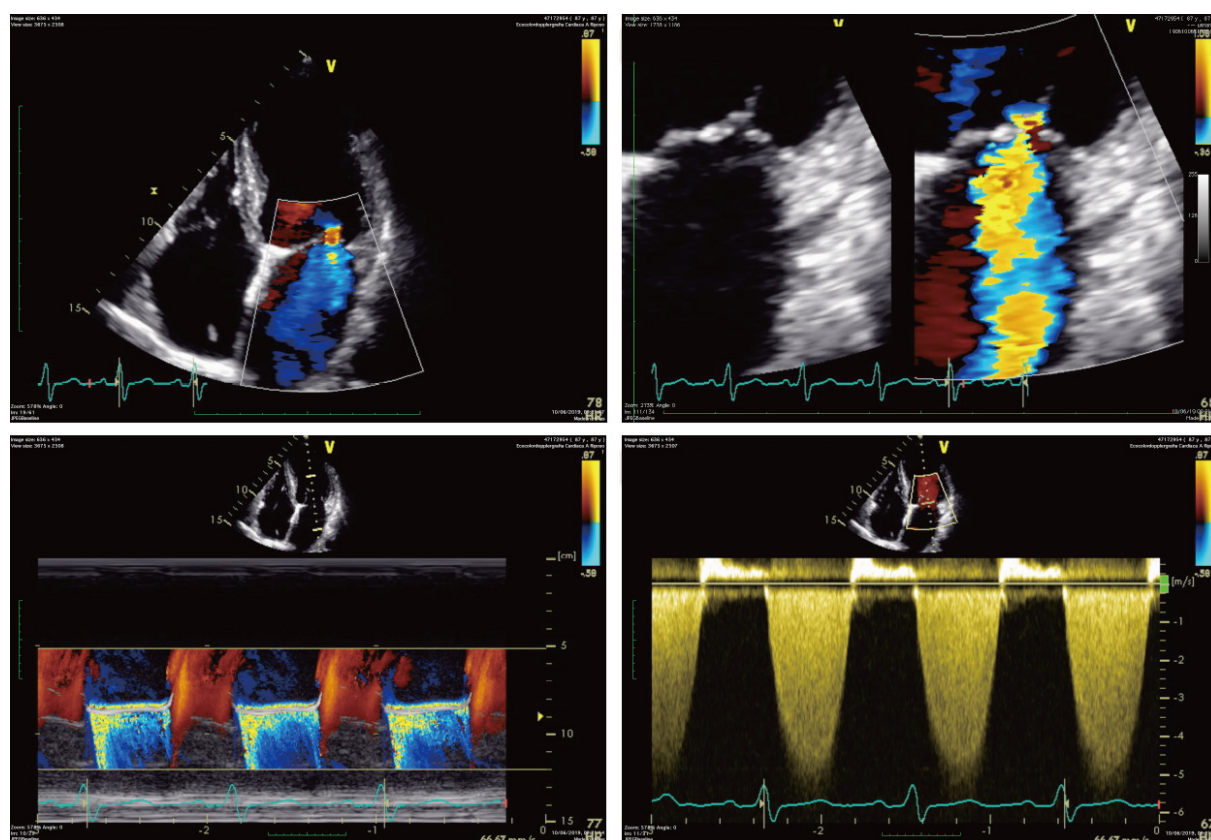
Pre-procedural transthoracic Doppler echocardiography evaluation of the mitral valve showing severe functional mitral regurgitation with a holosystolic central jet in a dilated cardiomyopathy (in particular: posterior leaflet of 8 mm, an effective orifice area of 30 mm² and a mitral valve area of 5 cm²)
